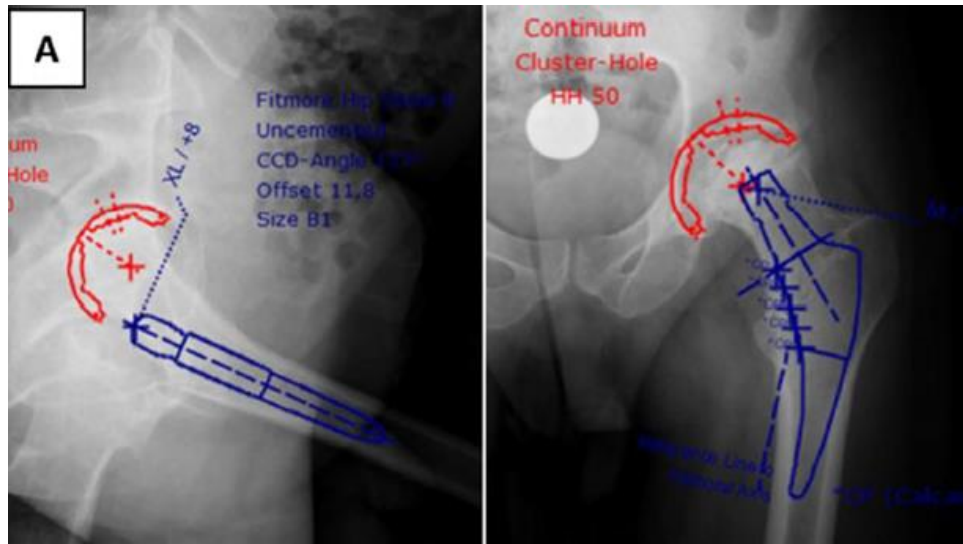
Upper) 2D frontal plane image (image from: Mirghaderi et al. 2022). Lower) 3D Computed Tomography scan with bony and implant geometry segmented (image from Müller et al 2011)
